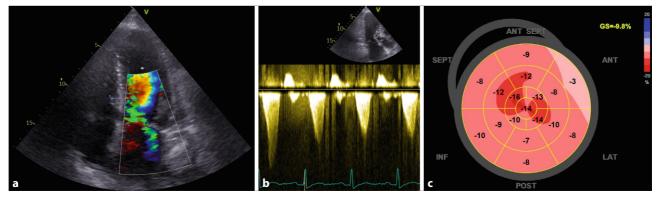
Patient with hypertrophic obstructive cardiomyopathy undergoing chemotherapy for bilateral high-risk breast cancer (a echocardiography showing excentric mitral regurgitation
